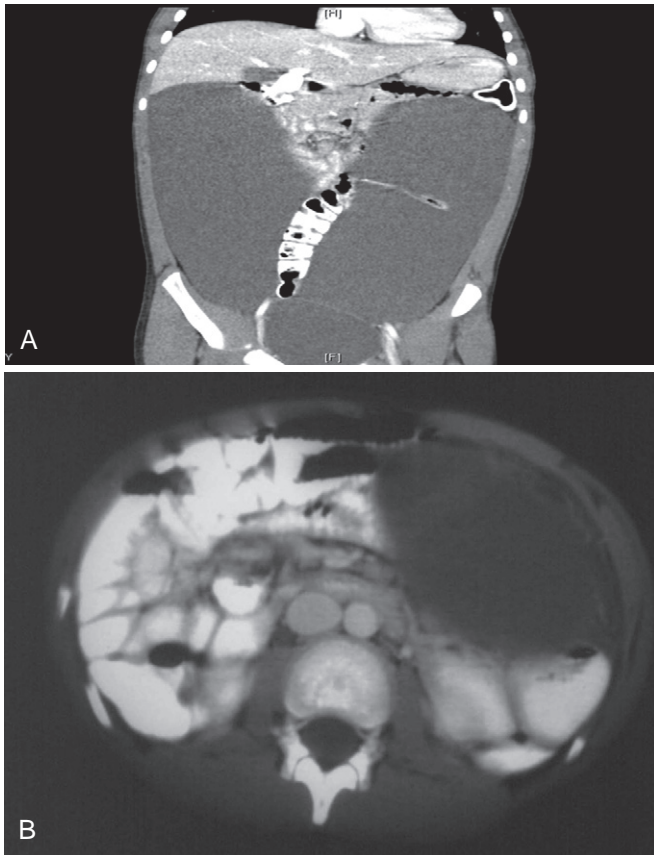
A, Computed tomography scan with gastrointestinal contrast showing a large cystic mass surrounding a loop of colon. B, Computed tomography scan demonstrating a large unilocular cyst that is displacing bowel loops laterally and posteriorly.
